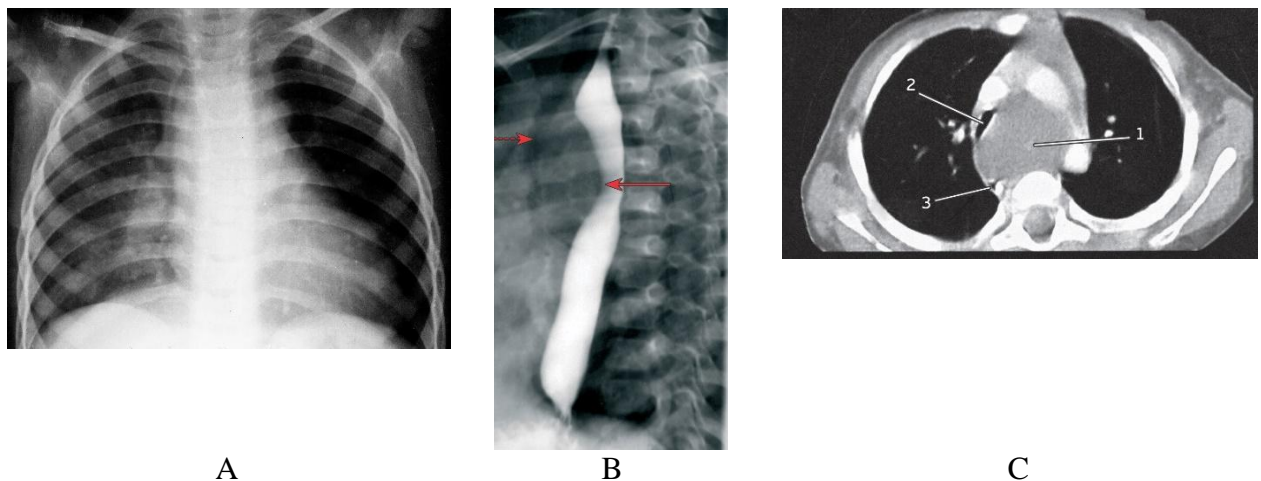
Bronchogenic cyst of mediastinum. A – Plain chest radiograph, ovoid shaped mass in the middle mediastinum, deviation of the trachea to the right, hyperlucent left lung (obstructive emphysema). B - right lateral esophagograph: compressive deformation of the esophagus (solid arrow), tracheal deviation (dotted arrow). C — CT with contrast enhancement, axial scan: compression and narrowing of the trachea, the cyst (1) squeezes and “pushes” the trachea (2) and esophagus (3).
